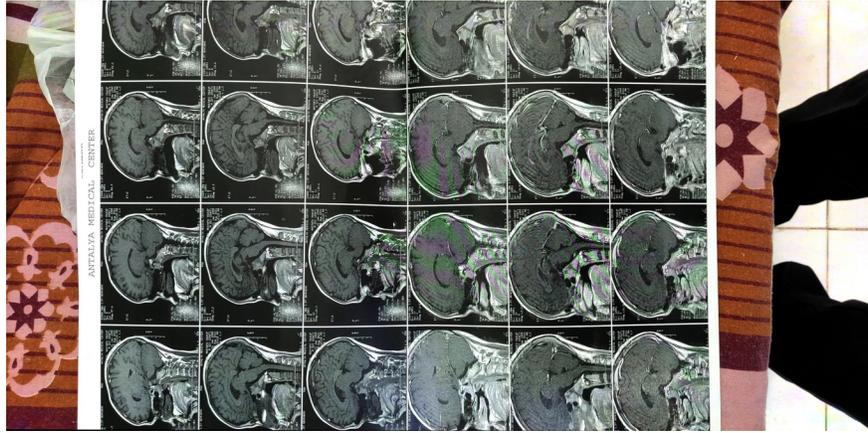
MRI Brain showing pituitary macroadenoma
